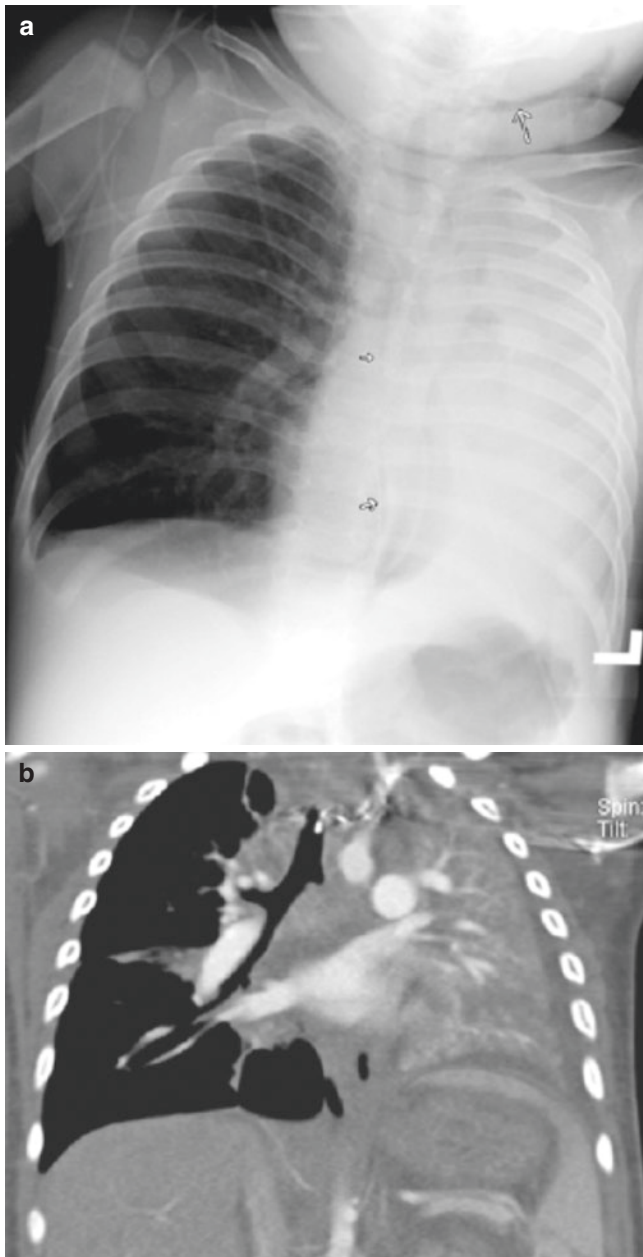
(a) CXR reveals collapse of the left lung. There is subcutaneous air in the left aspect of the neck (large arrow) consistent with a pneumomediastinum (small arrows). There is compensatory overinflation of the right lung, the mediastinum is shifted to the left. (b) CT confirms a complete obstruction of the proximal left main bronchus, but did not determine the exact nature of the obstructing process, a bronchial cast which was removed at bronchoscopy
